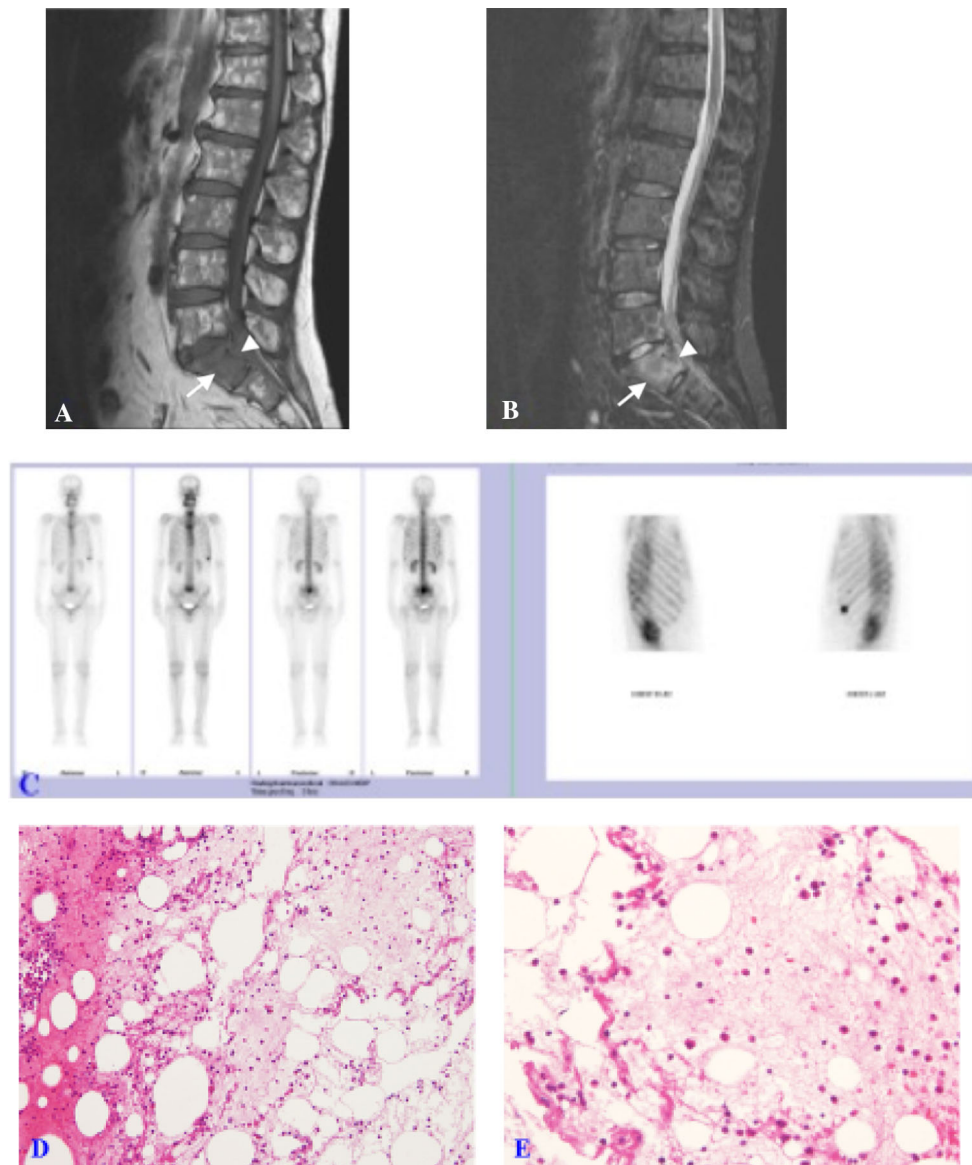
MRI examination of the 49-year-old man. One amorphous space-occupying lesion (*arrows*) with low signal intensity in T1-weighted image (a) and high signal intensity in short tau inversion recovery (STIR) images (b) is noted at the superior sacrum. Cortical
